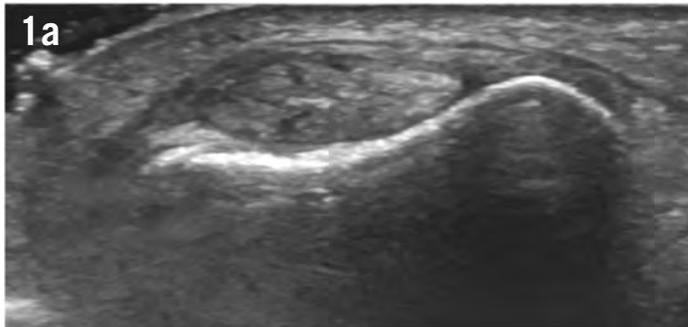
Professional golfer with overuse lead wrist ulna-sided wrist pain. Ultrasound demonstrates thickening of the extensor carpi ulnaris tendon with hypoechoic heterogeneous echotexture (a) compared to the asymptomatic other side (b). Extensor carpi ulnaris pathology is much more common in the lead wrist of professional golfers.
